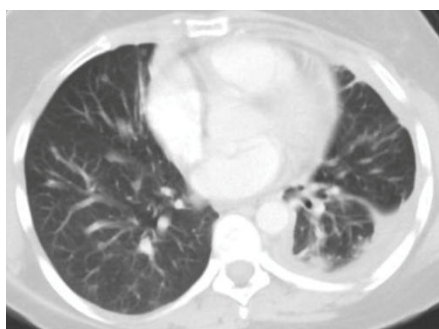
Bilateral pulmonary nodules and a rind of pleural thickening around the left lung on computed tomography, transverse view.
